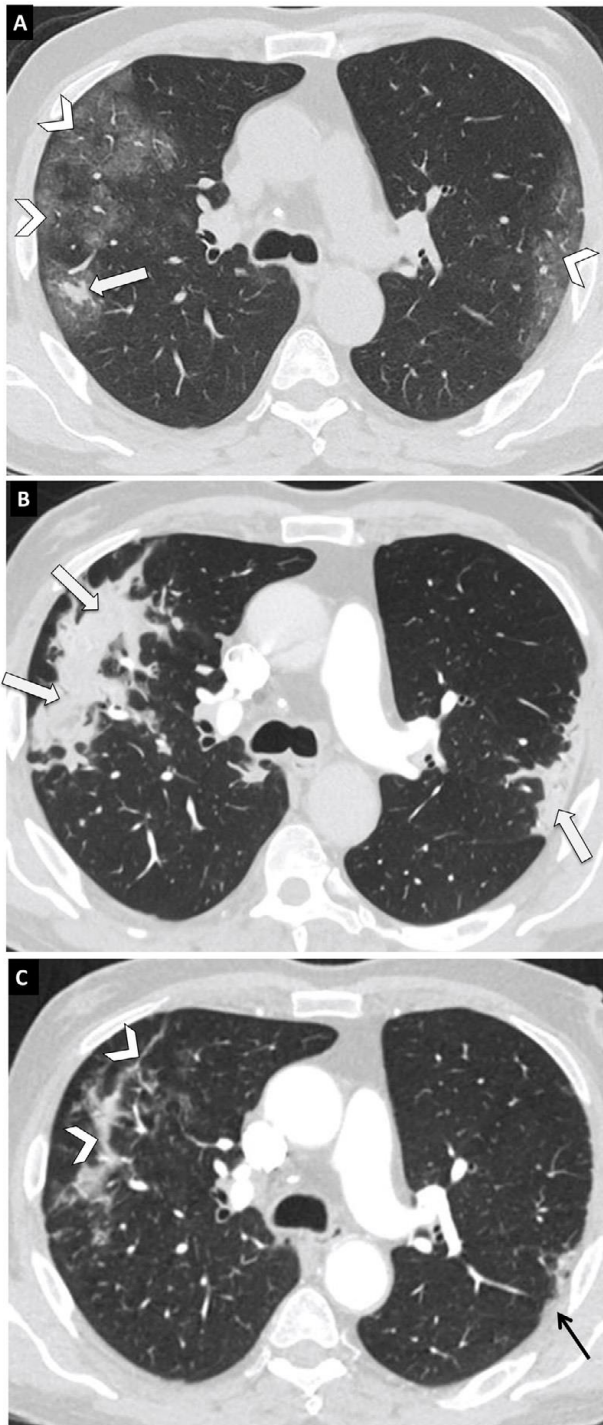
Progression of COVID-19 pneumonia in a 56-year-old woman. Axial chest computed tomography (CT) images with a thickness of 1 mm at the level of the carina [134].
